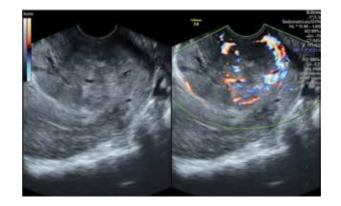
Ultrasound image in gray and color Doppler scale showing a rare case of choriocarcinoma of the cervix with intense vascularization.
